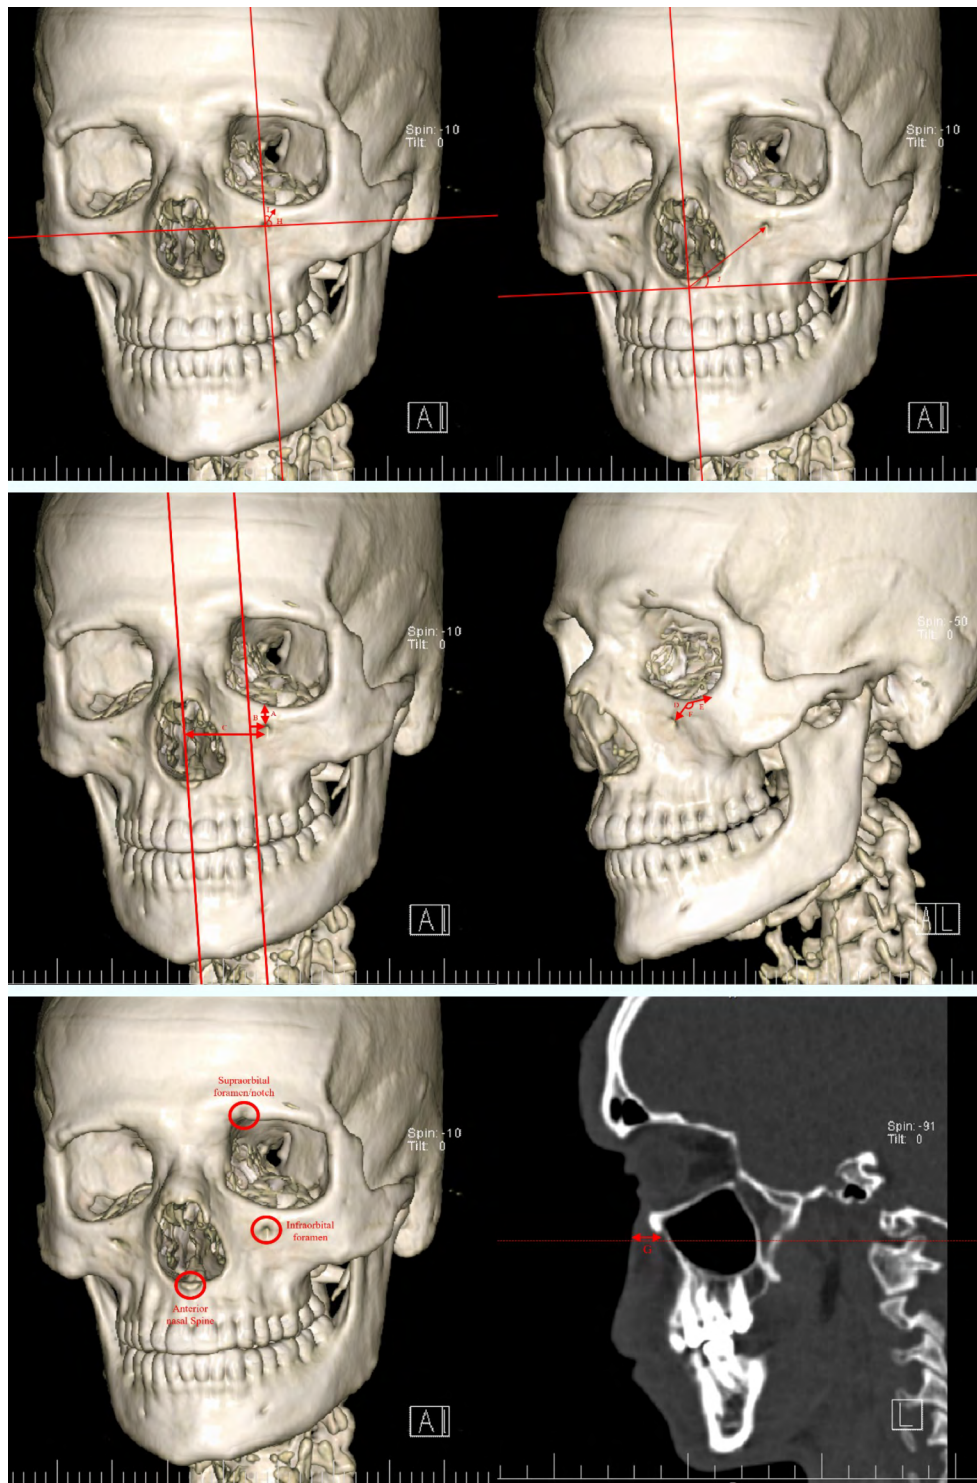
Radiographic identification of landmarks; (A) IOF-IOI distance; (B) IOF-SON distance; (C) IOF-midline distance; (D) IOC length; (E) IOG length; (F) IOC-IOG angle; (G) soft tissue thickness; (H) IOC-horizontal plane angle; (I) IOC-vertical plane angle; (J) IOF-ANS angle.
